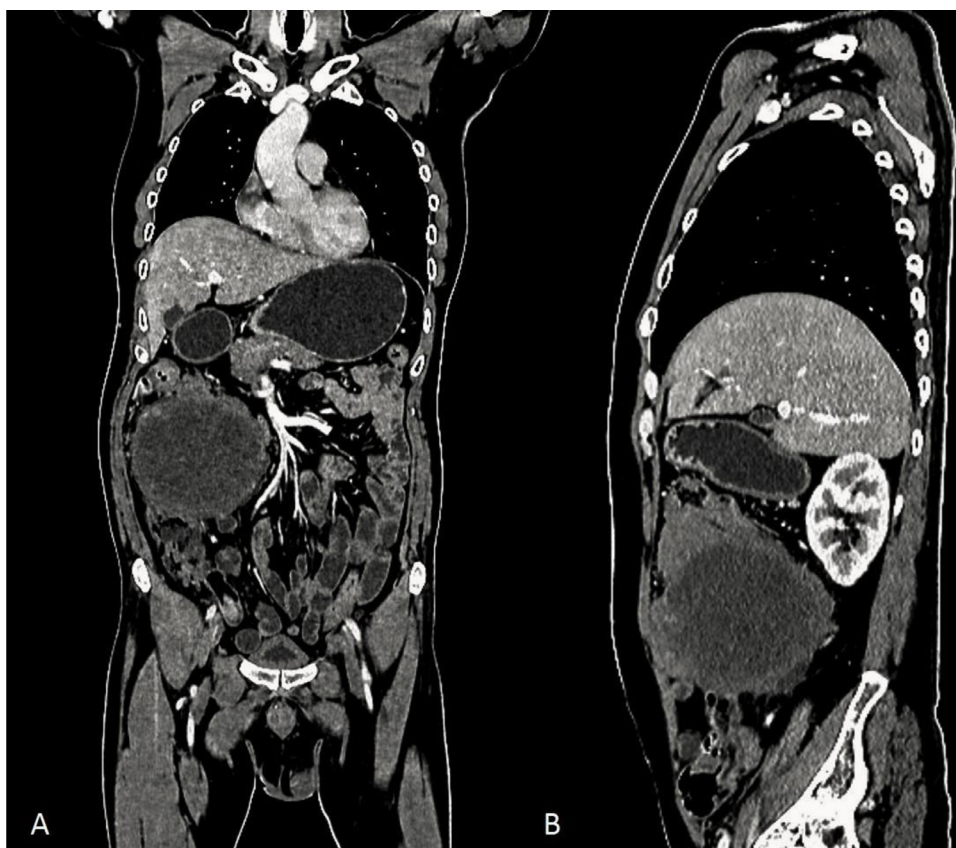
Primary malignant melanoma of the small intestine: contrast enhanced CT, showing heterogeneously enhancing lesion with areas of necrosis in mid abdomen on right side (A) coronal, superior mesenteric vein is normally visualized, (B) sagittal, fat plane with the right kidney is maintained.
